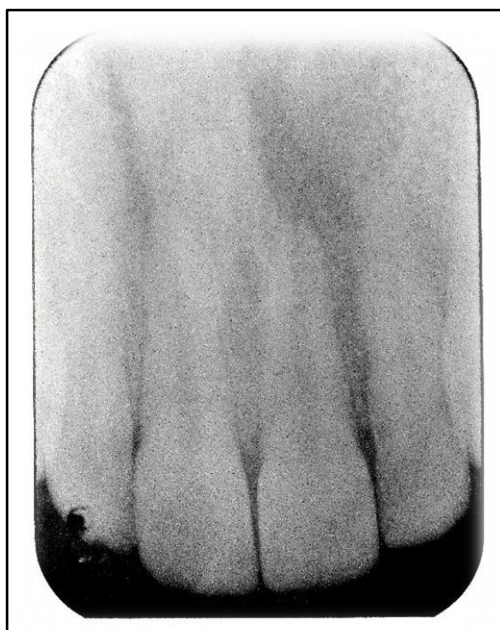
Aggressive Periodontitis- Radiographic image
